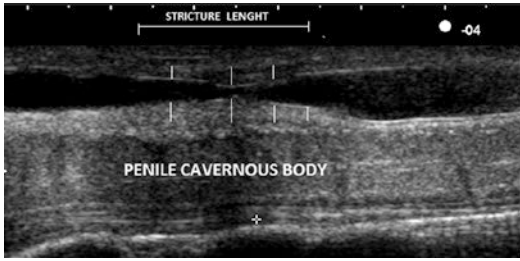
Ultrasound urethrogram showing a stricture in the penile anterior urethra, the abnormal mucosa is more extensive than estimated by just measurement of the length of the stricture
